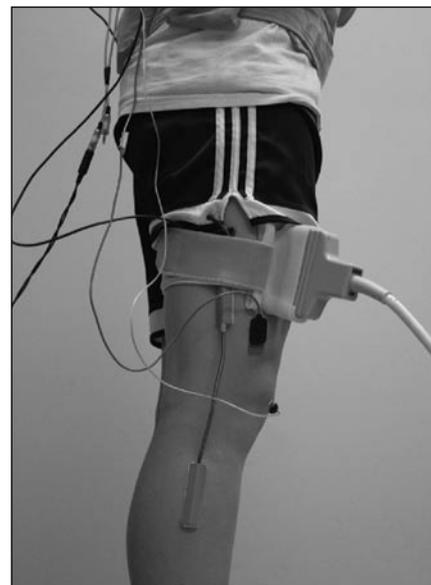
Experimental setup showing placement of ultrasound transducer, surface electrodes, and electrogoniometers.
